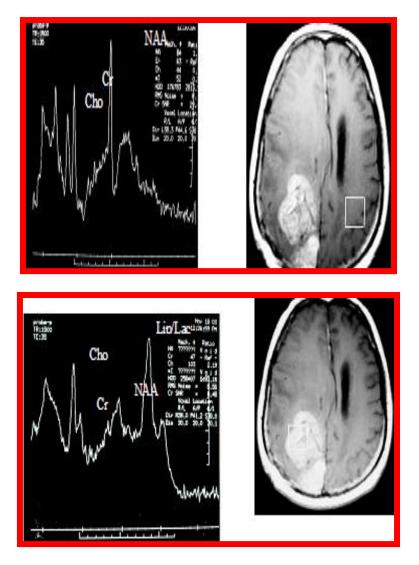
(A&B) shows MRI &MRS examinations for a male patient 42 years old was right occipital lesion proved pathologically to be glioblastoma multiforme.
